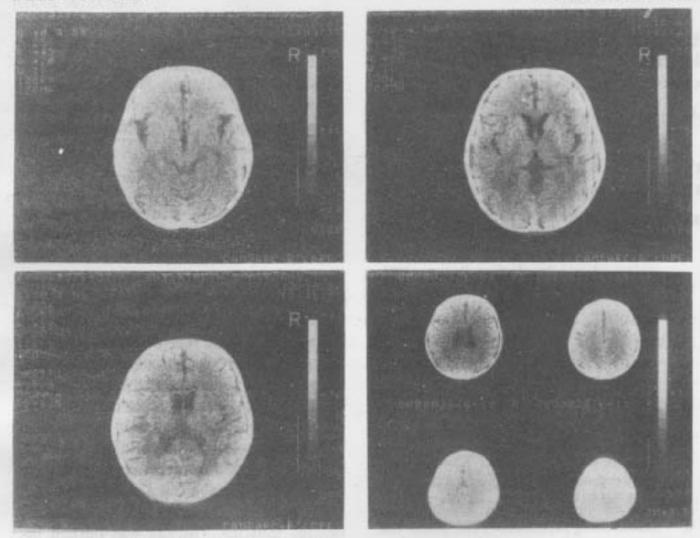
CT Scan of head showing bilateral symmetrical hypodensity in posterior parietal and occipital areas.
